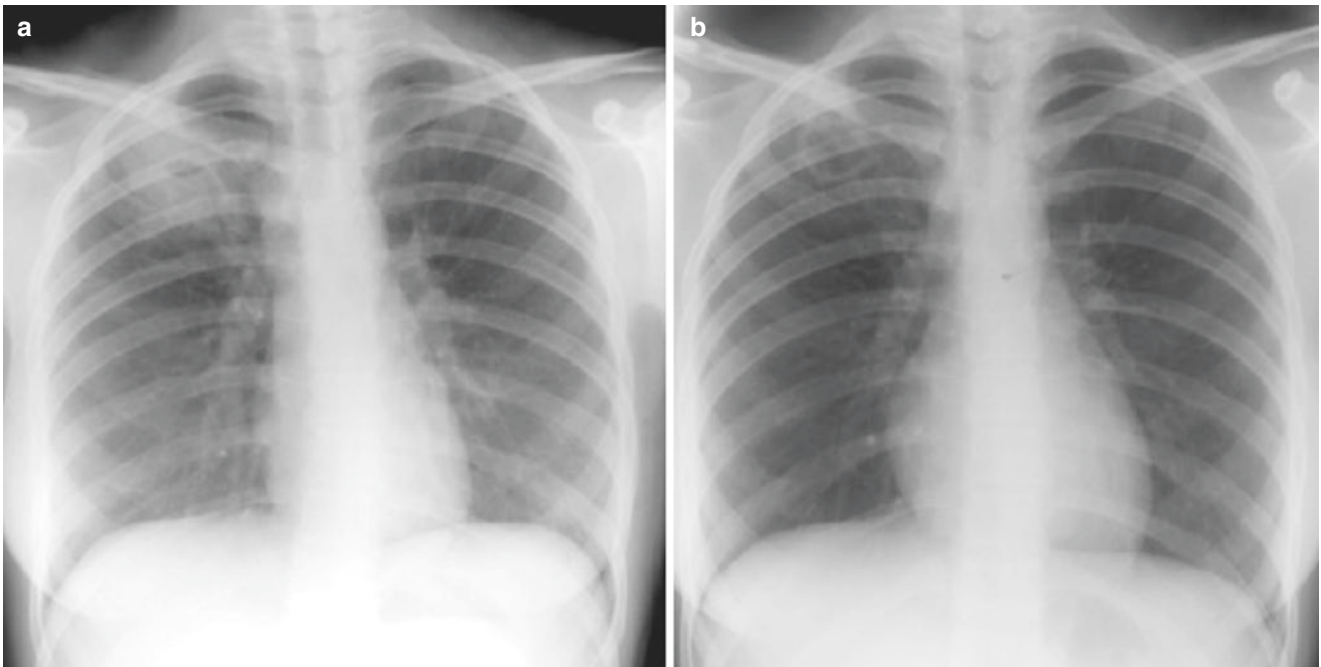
A 14-year-old girl who presented with a fever of 104 °F, cough, and right upper chest pain. (a) Initial chest radiograph demonstrates right upper lobe opacity with an air-fluid level, consistent with a lung abscess. Sputum cultures revealed *Staphylococcus aureus*. (b) A chest radiograph obtained 1 week later shows that the abscess develops into a thin-walled lucent structure, a pneumatocele
